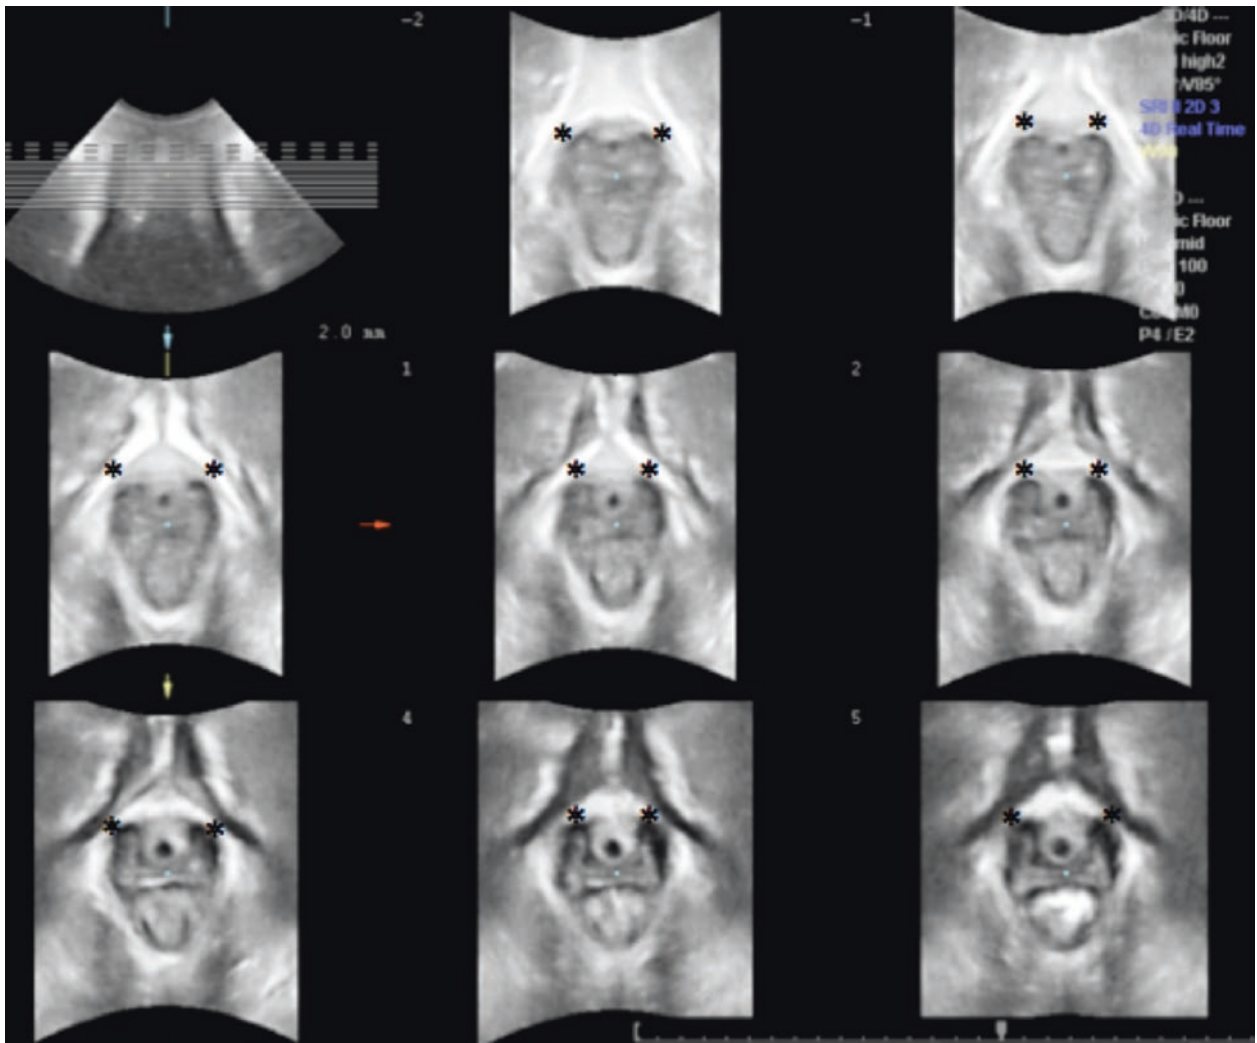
Fornices are assessed by tomographic ultrasound, with eight slices obtained from the plane of minimal hiatal dimensions to 12.5 mm above this plane. In the figure, the fornices are all intact (i.e., showing a
